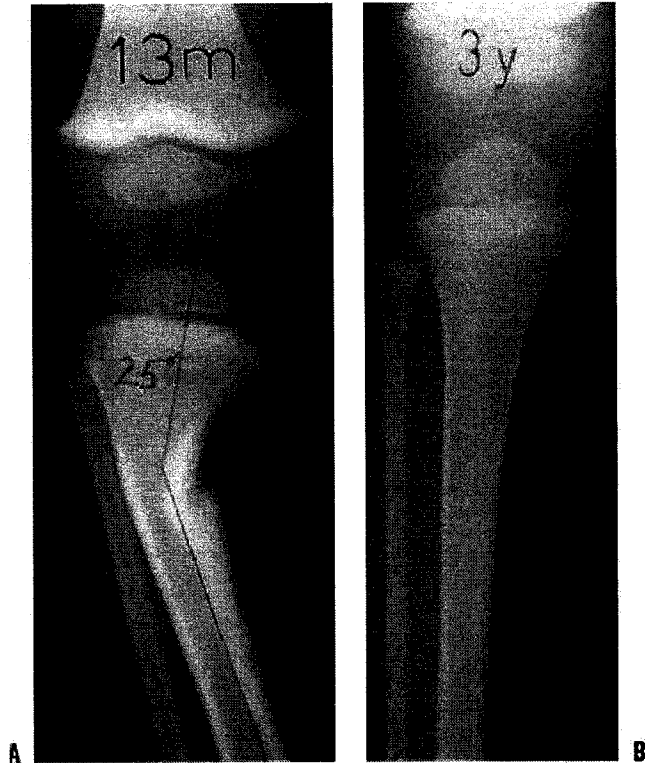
Focal fibrocartilaginous dysplasia. A: Initial radiograph of a patient at 13 months of age shows anterior and lateral bowing of the tibia, but bowing is more proximal than in congenital pseudarthrosis. B: The deformity resolved spontaneously, as seen in a radiograph made at 3 years of age.
